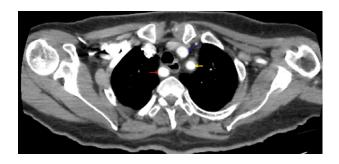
Postcontrast computed tomography—angiography axial image showing the arterial branching above the aortic arch: Truncus bicaroticus (blue arrow), left subclavian artery (yellow arrow), and Arteria lusoria (red arrow).
